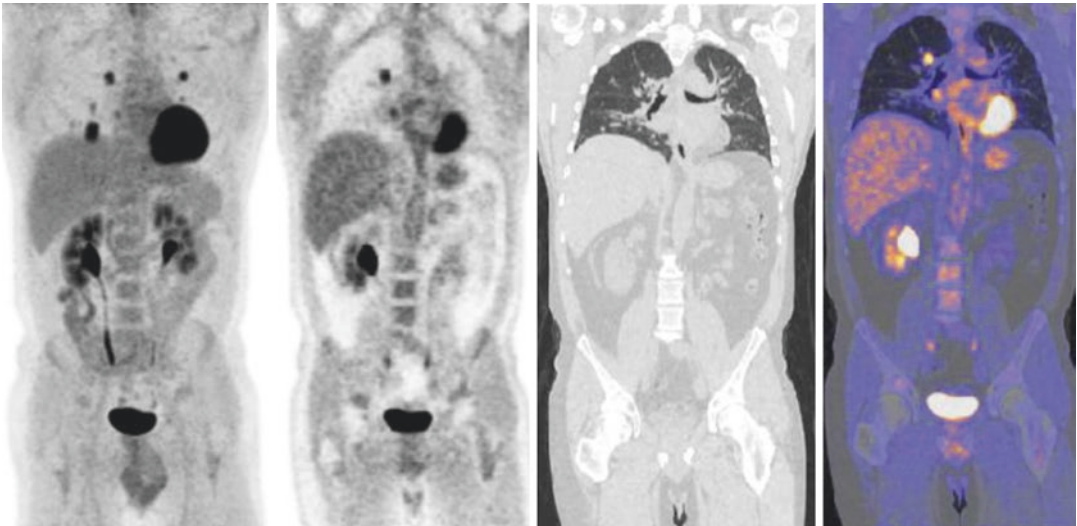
There are FDG-avid small volume pulmonary nodules and mediastinal lymph nodes.
